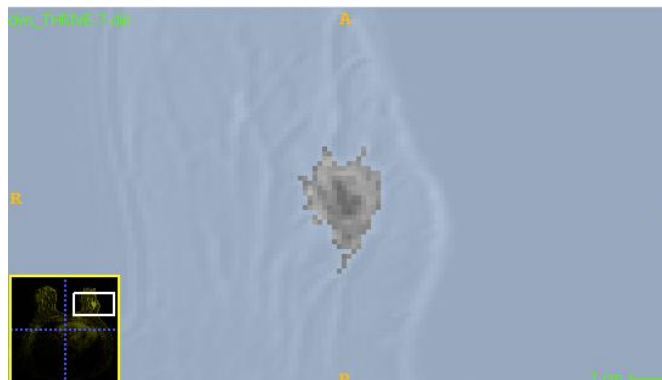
Example of an axial plane MRI on the background and the segmentation from *iSeg* highlighted in shades of grey.
